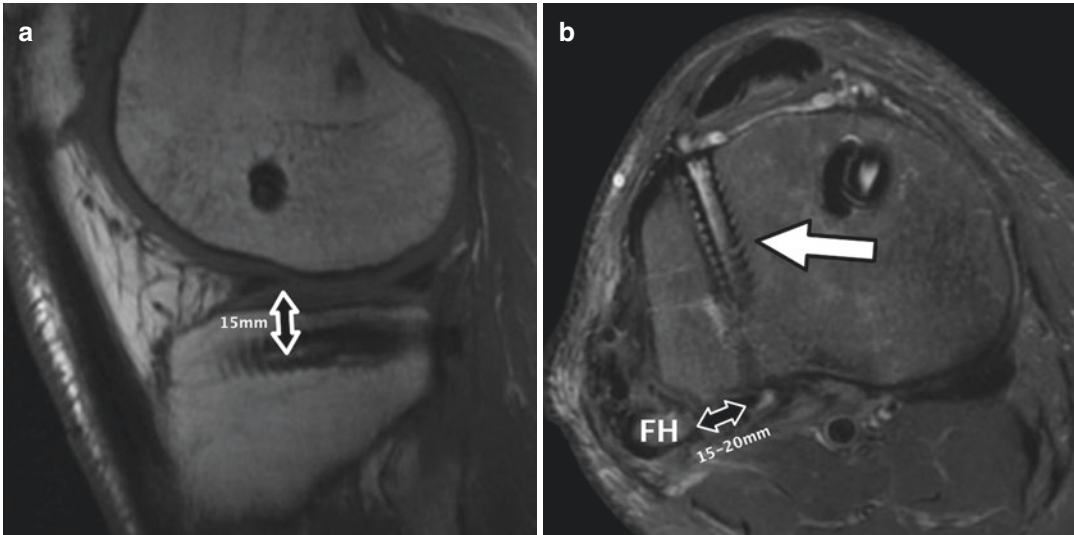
MRI of a right knee after a PLC including a tibial sling. (a) sagittal view; the graft and interference screw are seen in the antero-posterior tibial tunnel 15 mm distal to the joint line (arrow). (b) axial view;
